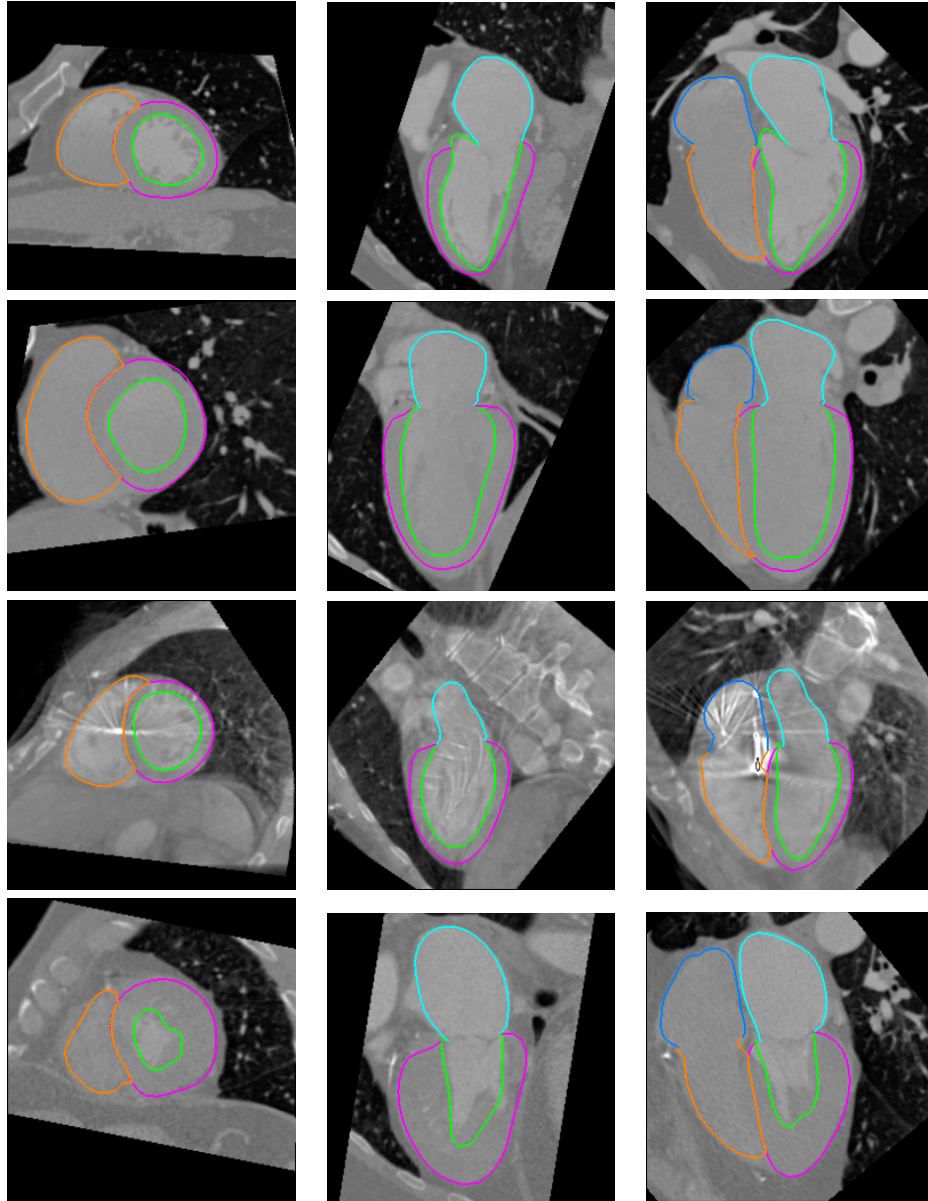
Examples of heart chamber segmentation in 3D CT volumes with green for LV endocardial surface, magenta for LV epicardial surface, cyan for LA, brown for RV, and blue for RA. Each row represents three orthogonal views of a volume.
